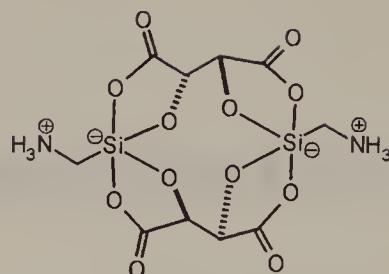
Structure of L-tartratodisilicate 1.2 from X-ray analysis.⁴
